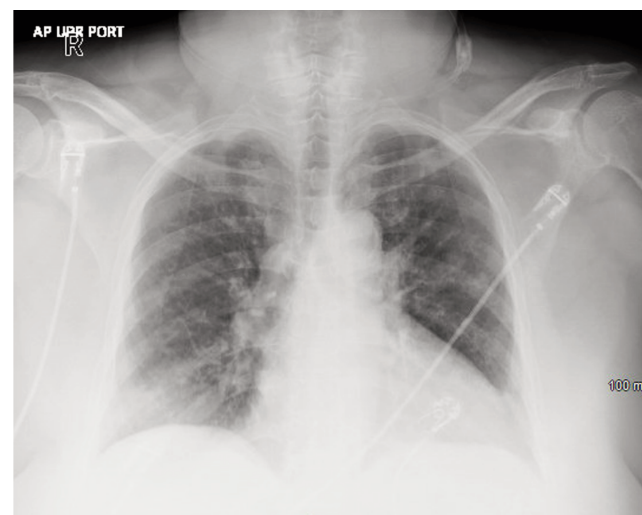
Chest X-ray obtained in the ED on presentation was notable for hazy bibasilar patchy opacities bilaterally, right greater than left. Mild increased interstitial markings as well.
